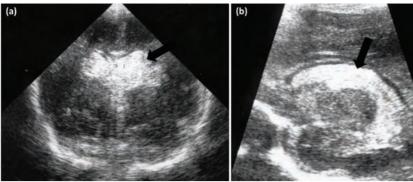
Coronal (a) and sagittal (b) ultrasound scans demonstrating hyperechogenic intraventricular haemorrhage (black arrows).
